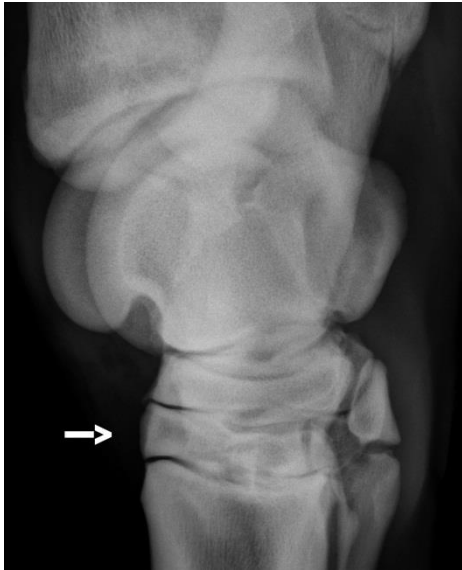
Dorsomedial-plantarolateral radiographic view of tarsus showing wedging of the third tarsal bone (arrow).
